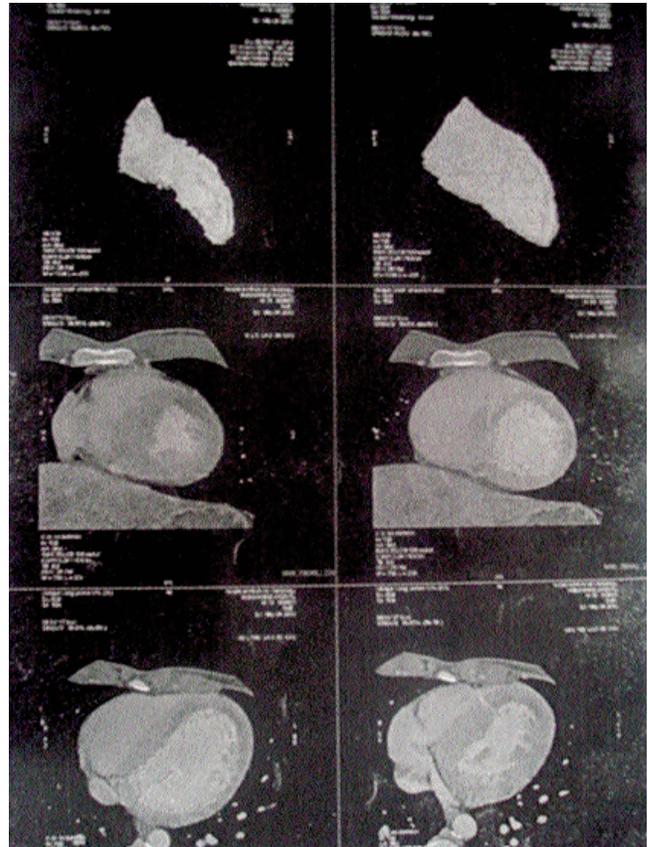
CT angiogram showing supra-ventricular stenosis.
